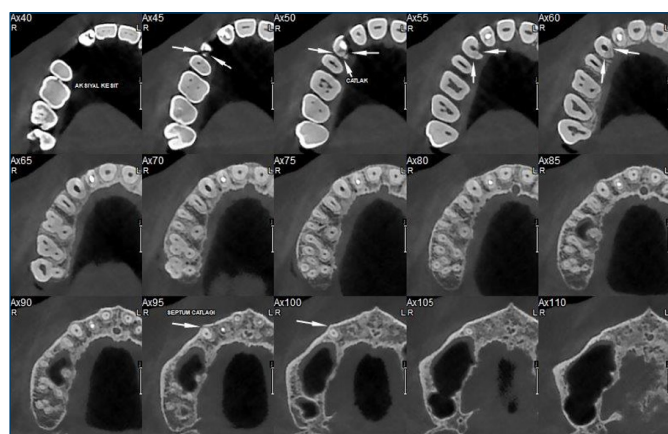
Axial CBCT images at the beginning
